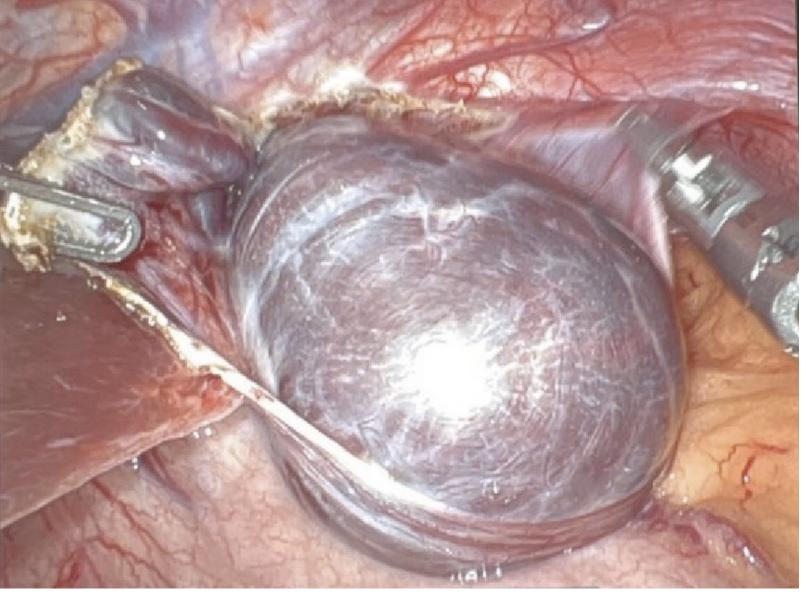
Abdominal CT scan 1 month prior to surgery Fig 2) Intra-operative picture of tumor while mobilizing
